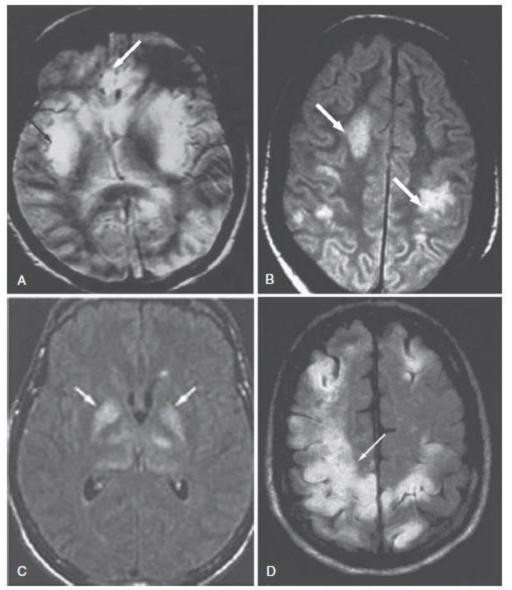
Typical magnetic resononance imaging (MRI) changes associated with viral encephalitis. A, Herpes simplex virus type 1 encephalitis with increased TZ-weighted signal in bilateral temporal lobes. Increased signal does not extend beyond the insular cortex (black arrow) but does involve the cingulate gyrus (white arrow). B, Varicelia-zoster virus vasculopathy on proton-density MRI scan with multiple areas of infarction in both hemispheres (arrows). C, West Nile virus encephalitis with increased signal on FLAIR MRI of the basal ganglia (arrows). D, Enterovirus encephalitis with increased signal intensity on FLAIR MRI in both hemispheres, greater on the right, in the posterior cerebral hemisphere (arrow). (Modified from Gilden DH, Mahalingam R, Cohrs RI, Tyler KL. Herpesvirus infections of the nervous system. Nat Clin Pract Neurol. 2007;3:83; and Debiasi RI, Tyler KL. West Nile virus meningoencephalitis. Nat Clin Pract Neurol. 2006;2:264.)
